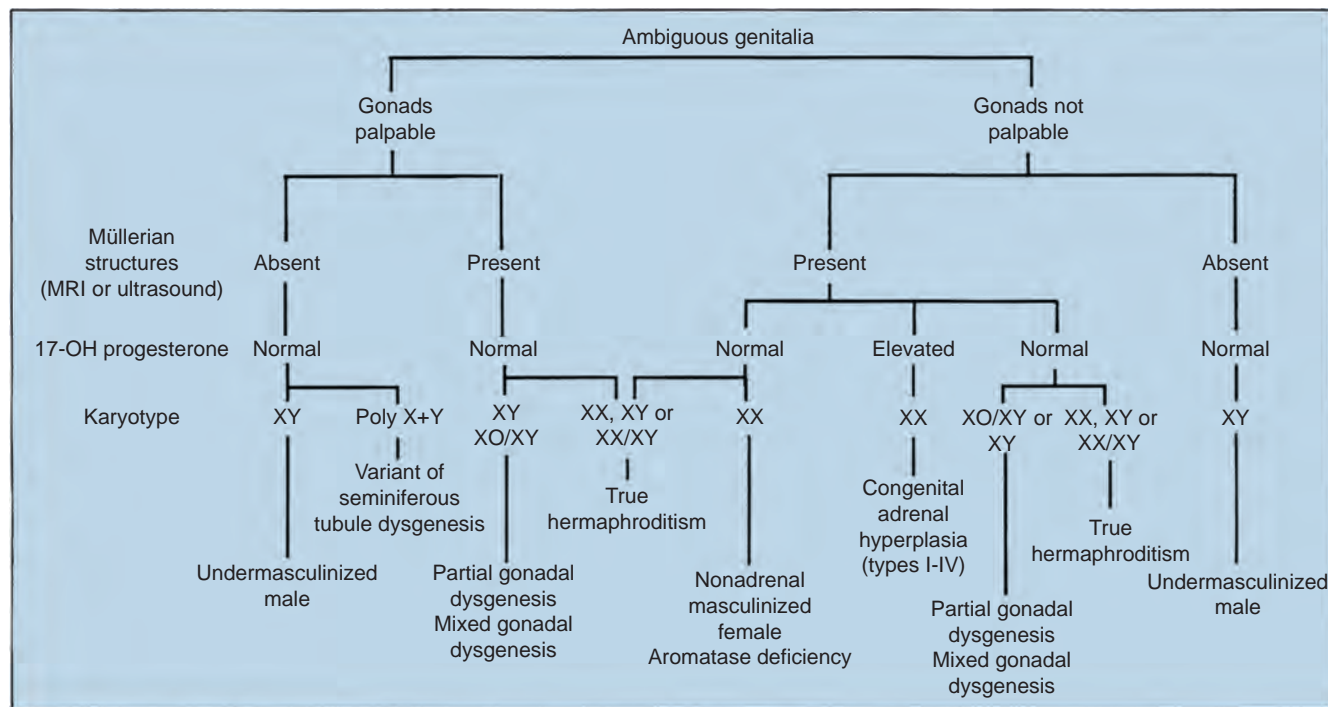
Diagnostic algorithm for a newborn with ambiguous genitalia based on gonadal palpability, presence or absence of müllerian structures, 17-hydroxyprogesterone concentration, and karyotype. MRI, magnetic resonance imaging (Modified from Grumbach MM, Conte FH. Disorders of sex differentiation. In: Wilson JD, Foster DW, editors. Williams textbook of endocrinology. Philadelphia: Saunders; 1998. p. 1401.)
